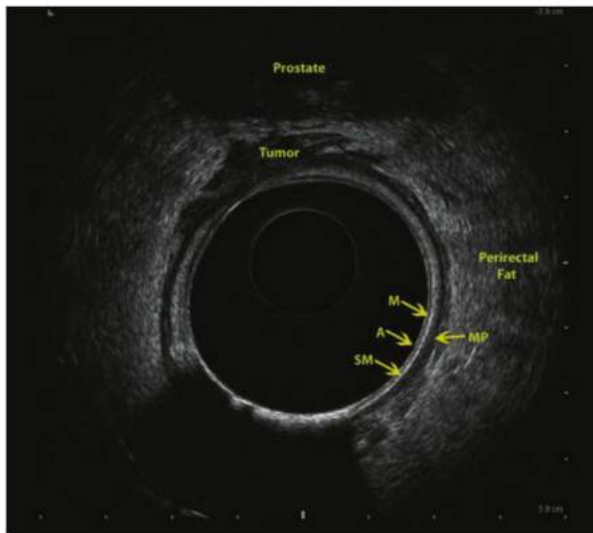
• Endoscopic ultrasound (EUS) depicts the bowel wall layers: A indicates balloon interface, M indicates mucosa/muscularis mucosa, SM indicates submucosa, and MP indicates muscularis propria. This patient has an anteriorly located tumor with invasion of the perirectal fat but no direct extension into the prostate (EUS T3).
